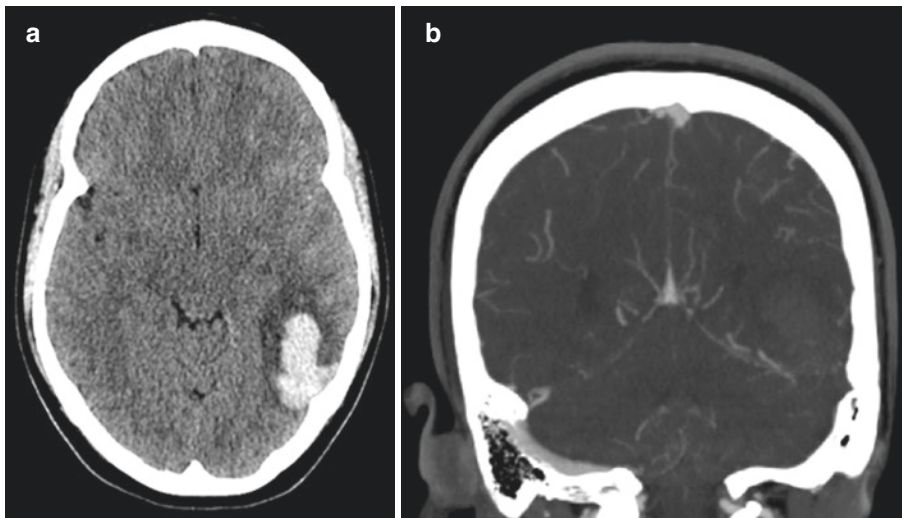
CT brain of Left temporo-parietal ICH and CT venogram demonstrating occlusion of left sigmoid sinus by thrombus
